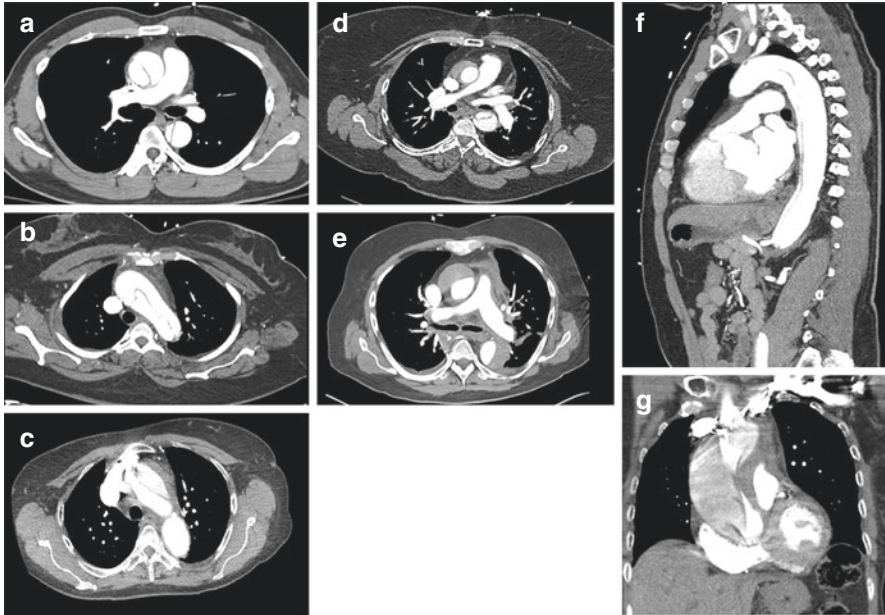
Representative computed tomography images demonstrating acute type A aortic dissection. First panel top (a) Axial view with type A aortic dissection visible in ascending and descending aorta. First panel middle (b) Axial view with type A aortic dissection visible in the aortic arch (Previously published in Lawton JS. Acute type A aortic dissection 101. *J Thorac Cardiovasc Surg* 2015;150:769–770). First panel bottom (c) Axial view with type A aortic dissection visible in the proximal aortic arch. Second panel top (d) Axial view with type A aortic dissection with classic flap visible in the descending aorta and intramural hematoma in the ascending aorta. Second panel bottom (e) Axial view with type A aortic dissection with intramural hematoma visible in the ascending and descending aorta. Third panel top (f) Sagittal view with type A aortic dissection visible in the descending aorta. Third panel bottom (g) Coronal view with type A aortic dissection visible in the ascending aorta and proximal arch
